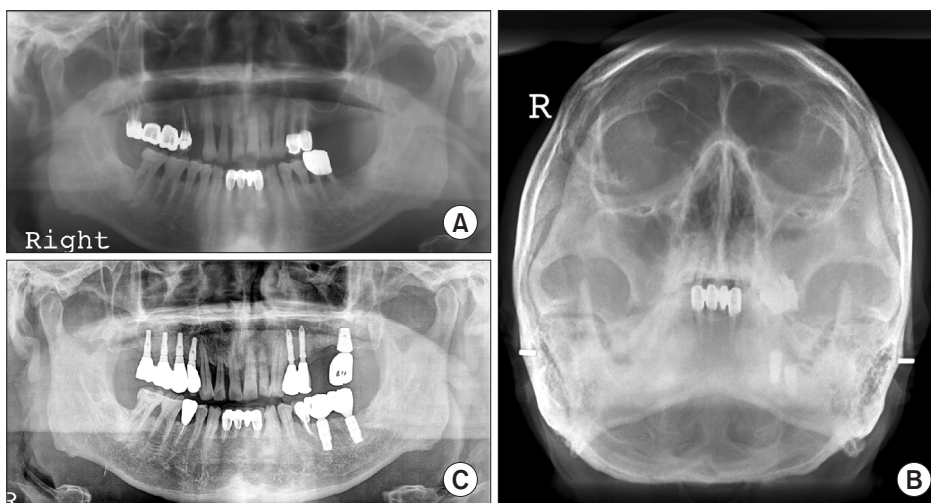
Change in alveolar bone height (Case 4). A. Preoperative panoramic radiograph. B. Water's view two weeks after bone graft: left maxillary sinusitis developed. C. Panoramic radiograph 53 months after sinus bone graft: the second molar implant was removed and a new implant was placed at a distal area. The first molar implant was also removed.
